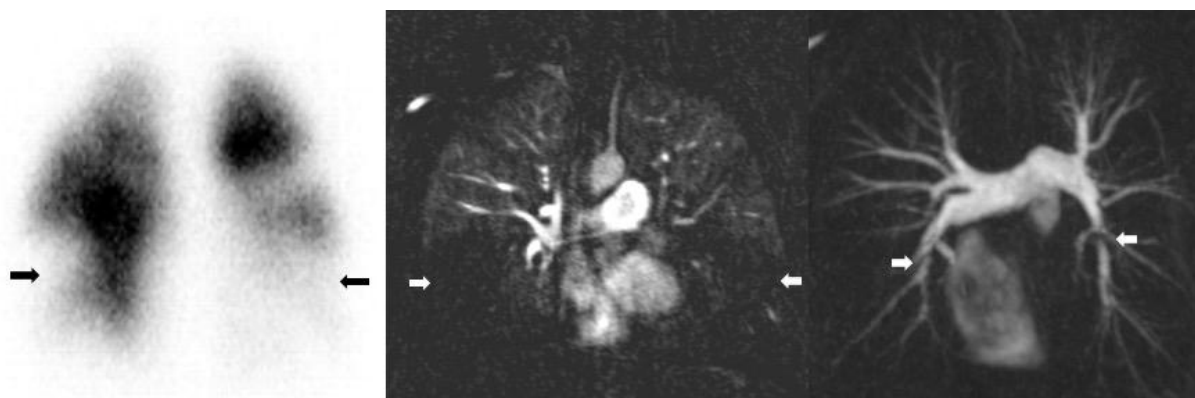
MR perfusion and angiography. 70-year-old male with CTEPH with large bilateral perfusion defects in both lower lobes on the MR perfusion (mid panel). The corresponding MR angiography (right panel) demonstrates significant trifurcation webs in both lower lobes. There is good concordance with VQ scintigraphy (perfusion component, anterior view, left panel).
